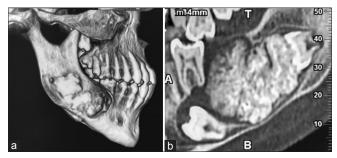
(a) Three-dimensional reconstruction showing the extent of the tumor. (b) Sagittal computed tomography section exhibiting impacted 47, 48 within the mixed lesion
